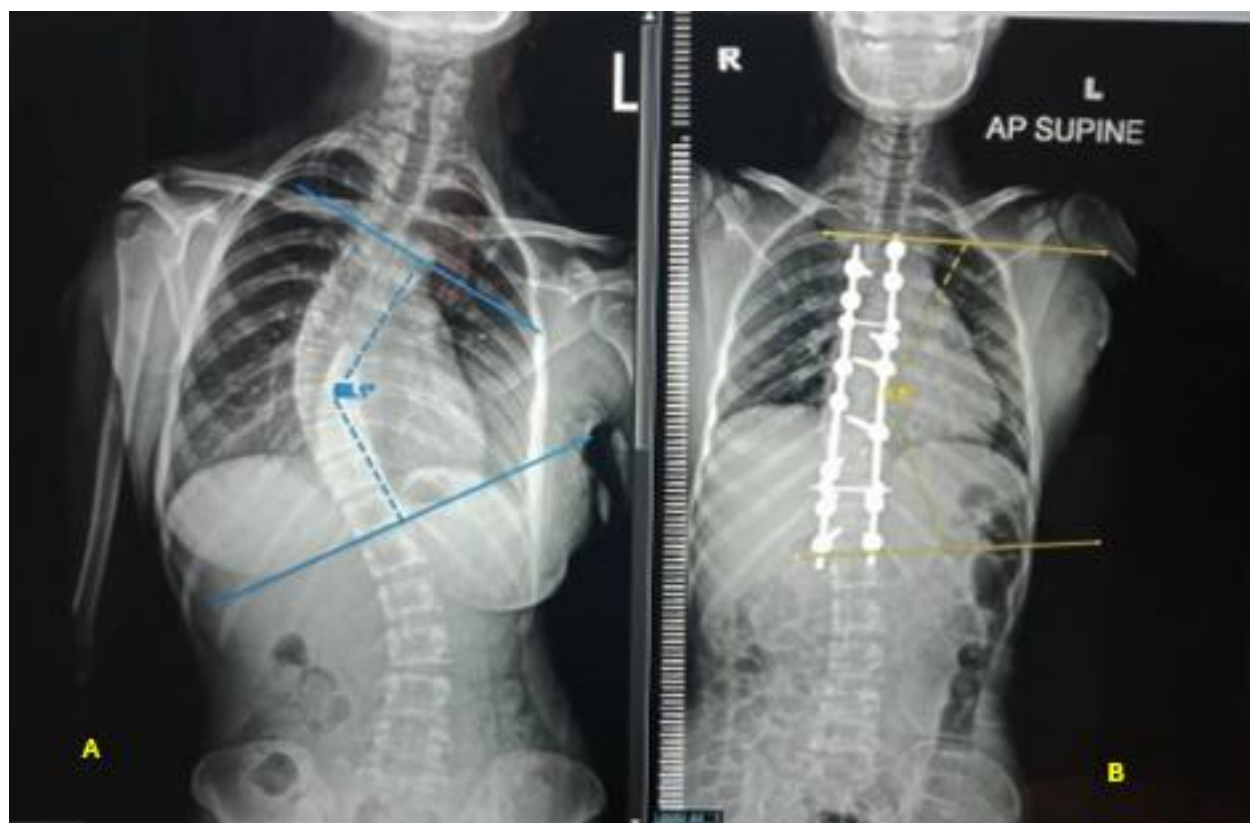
A and B shows radiograph images of Cobb angle correction following surgery.
